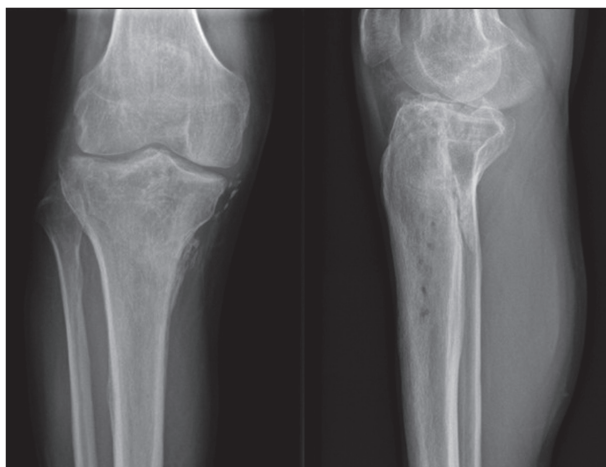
X-rays 12 months after trauma.
